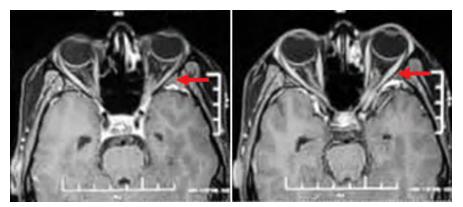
MRI of the brain + orbit showing enhancement of the left optic canal with traversing structures (marked by red arrow)
